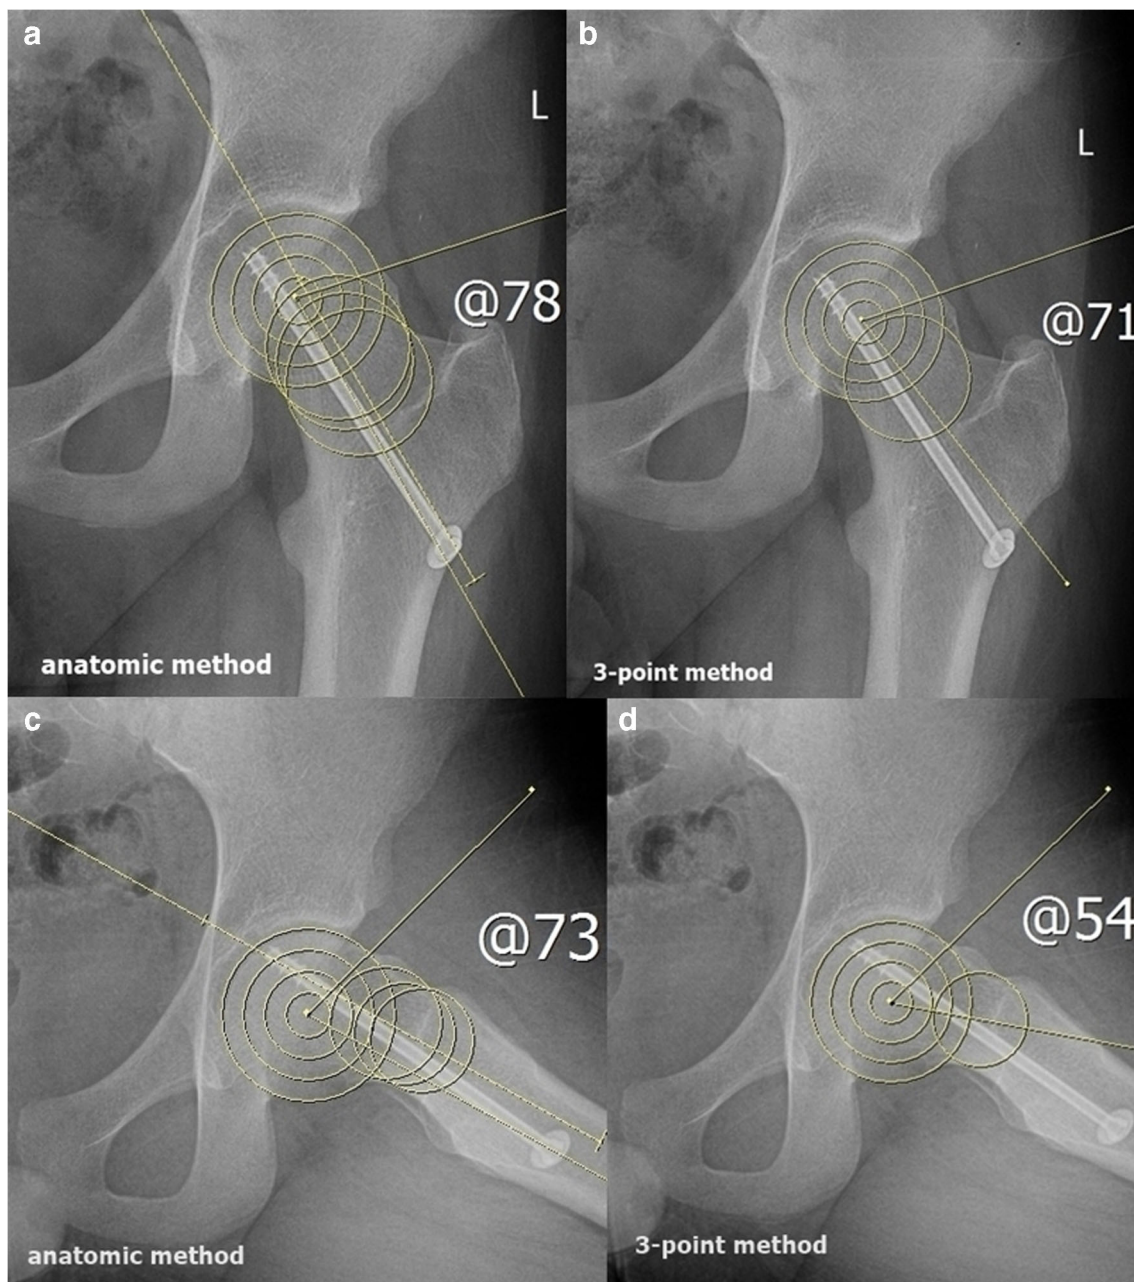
a, b Anterior–posterior and c, d lateral radiographics of the hip demonstrating the alpha angle measurement according to the three-point method and the anatomical method
